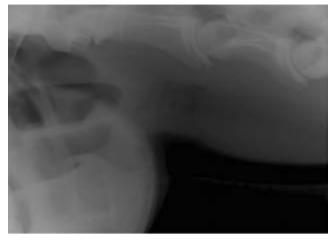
Plain cranial cervical radiograph showing the mass protruding ventrally ventral to the third and fourth cervical vertebrae. The cranial limit of the mass is also visible.
